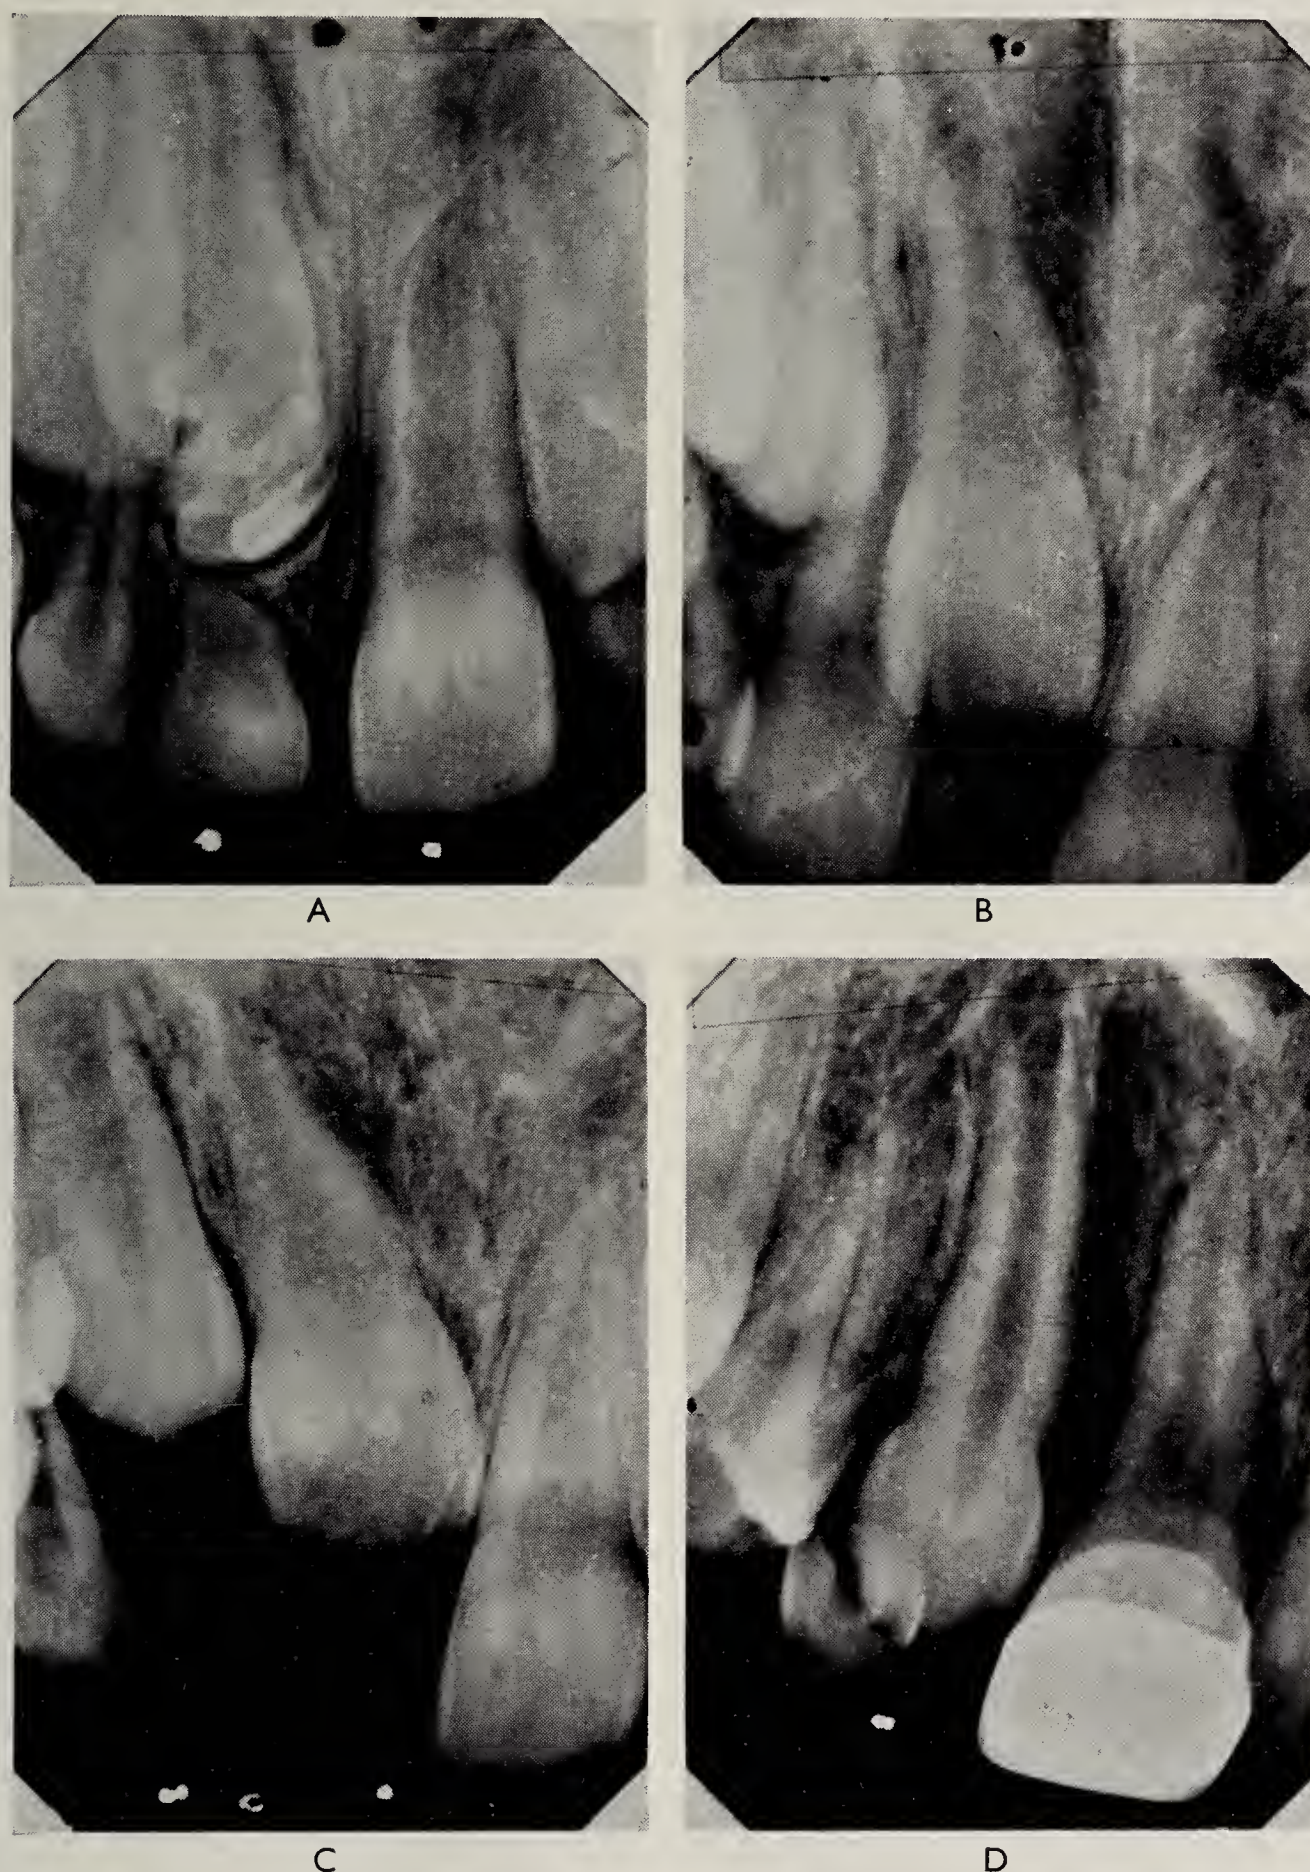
Case 2.* Odontome-like supernumerary. A, Preoperative X-ray; note level of 2| and 1|. B, One year later, before extraction of 2| which has erupted; 1| position has not improved. C, Six months after extraction 2|, 3| appears to be contributing to increased mesio-angular inclination of 1|. D, Nine months after capping.
